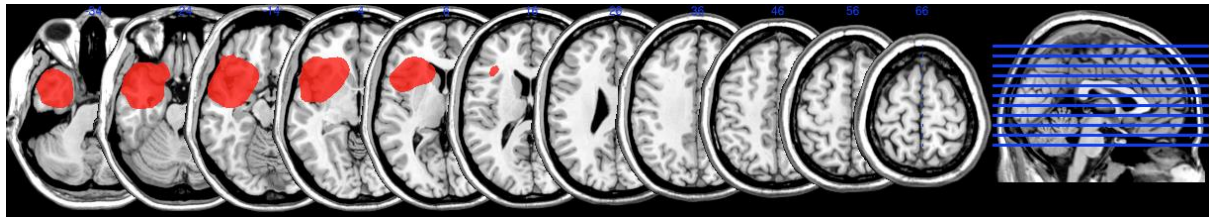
MRI scan of patient CA
